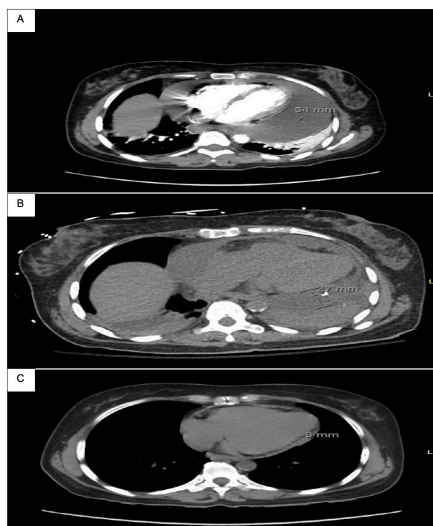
The changes in the size of the patient's pericardial effusion throughout her treatment course. (A) The patient's initial CT angiogram of the chest. Note the very large pericardial effusion on presentation measuring 54 mm in the widest portion. (B) Size of pericardial effusion 2 days after initial pericardiocentesis. Note there is still a moderate-sized residual pericardial effusion after pericardiocentesis measuring 27 mm. (C) The CT of the chest 3 months after discharge. Note that there is only a minimal amount of fluid measuring 8 mm.
